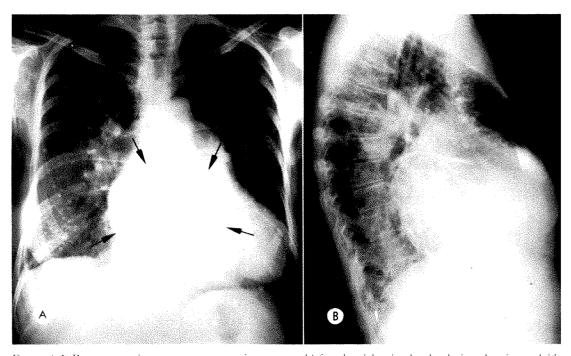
(A) Posteroanterior roentgenogram of a 41 year old female with mitral valve lesion showing calcific tion in the left atrial wall (arrows), and pulmonary ossifications. (B) Lateral roentgenogram of sai patient.
